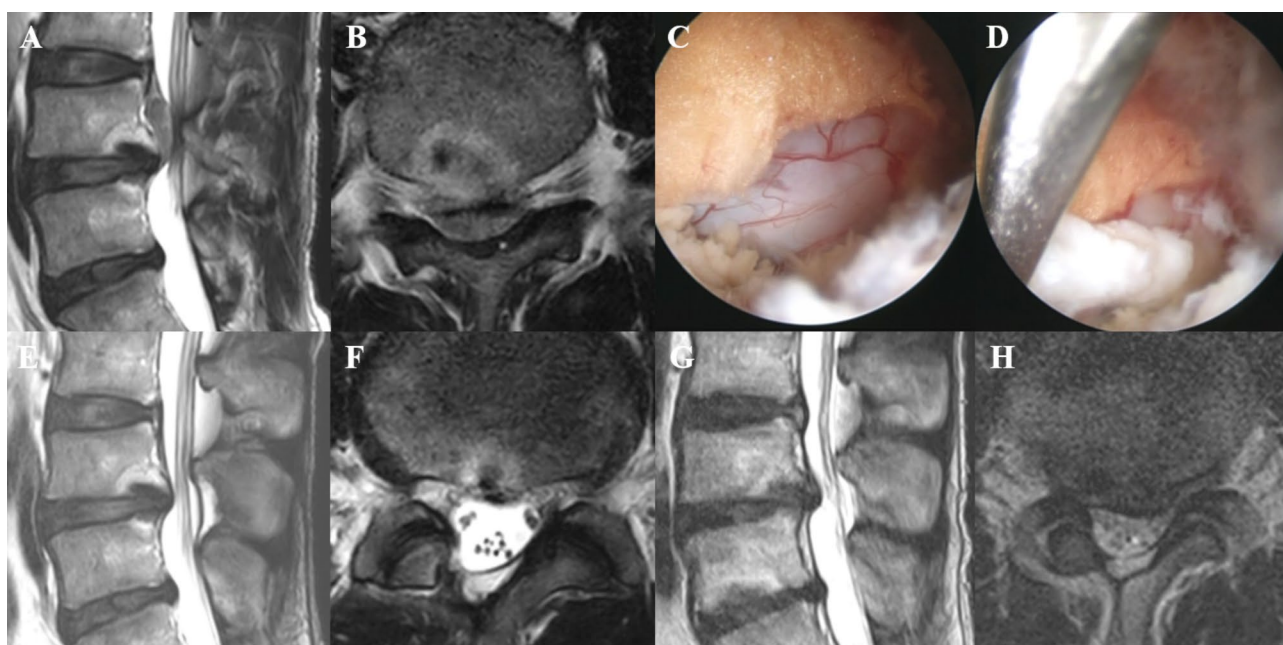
Biportal endoscopic discectomy in a 34-year-old man (Case 13). (a, b) Severely herniated intervertebral disc at L4-5 with highly migration to superiorly was showed in MRI. (c, d) Intraoperative endoscopic images showed partial ligamentum flavectomy and disc resection using pituitary rongeur. (e, f) Postoperative MRI showed fully removed herniated disc with minimally damaged paraspinal muscle. (g, h) Postoperative 3-year MRI showed minimally damaged paraspinal muscle and ligamentum flavum with partial disc recurrence at L4-5
